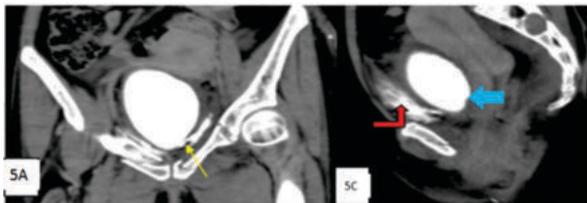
CT Cystography coronal (fig 5A) and sagittal (fig.5B) showing a defect in the left inferolateral wall of the bladder (yellow arrow) with extravasation of contrast into anterior (red arrow) and lateral perivesical space, suggesting extraperitoneal bladder rupture. Sky blue arrows mark the urinary bladder.
